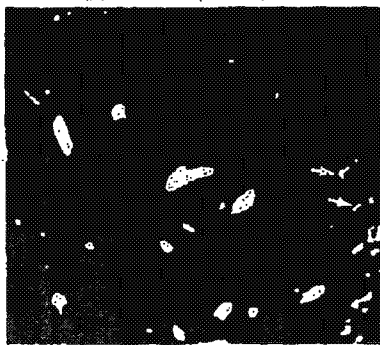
Patient with minimal asbestosis. High-resolution CT scan of an isolated lobe shows only focal interstitial thickening (arrows). The high-resolution CT was judged as mildly abnormal and unlikely to represent asbestosis.
